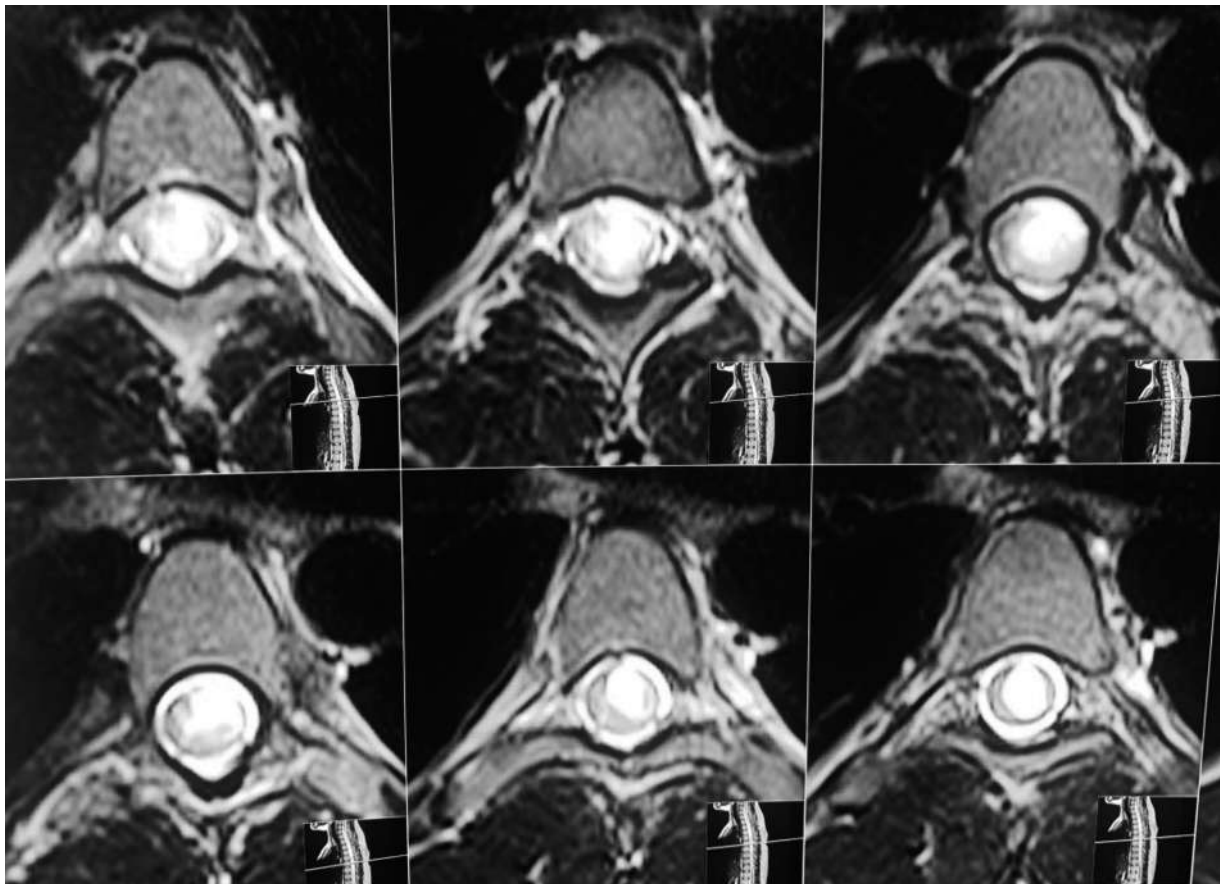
Preoperative magnetic resonance imaging (MRI) scan of the dorsal spine with contrast showing the intramedullary contrast-enhancing lesion.
